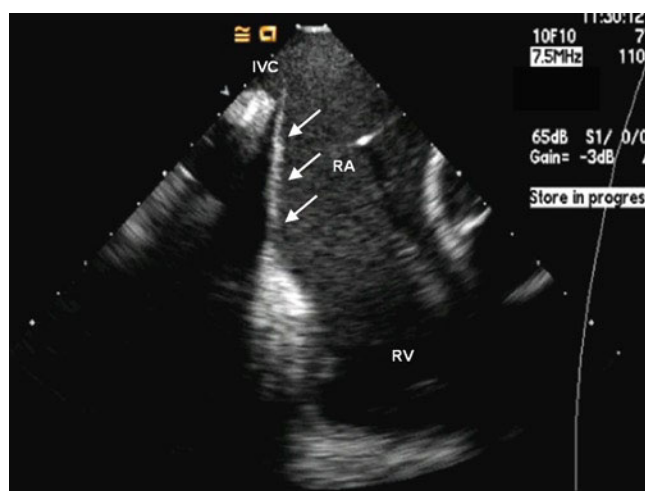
Intracardiac echocardiography imaging from the right atrium demonstrating a flat cavo-tricuspid isthmus. The isthmus is denoted by the arrows. IVC inferior vena cava, RA right atrium, RV right ventricle
